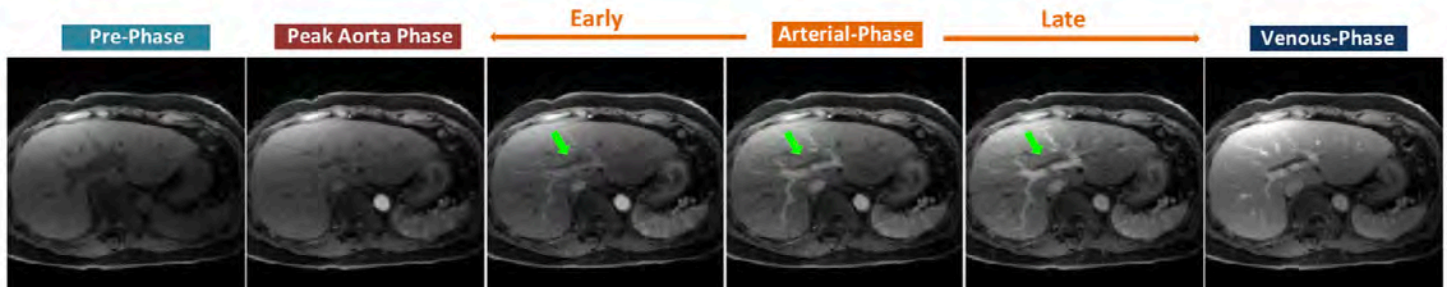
Fast free-breathing 3D dynamic contrast-enhanced MRI (DCE-MRI) of the liver using the GRASP technique. High resolution contrast-enhanced liver images at multiple time points can be obtained for clinical use.
